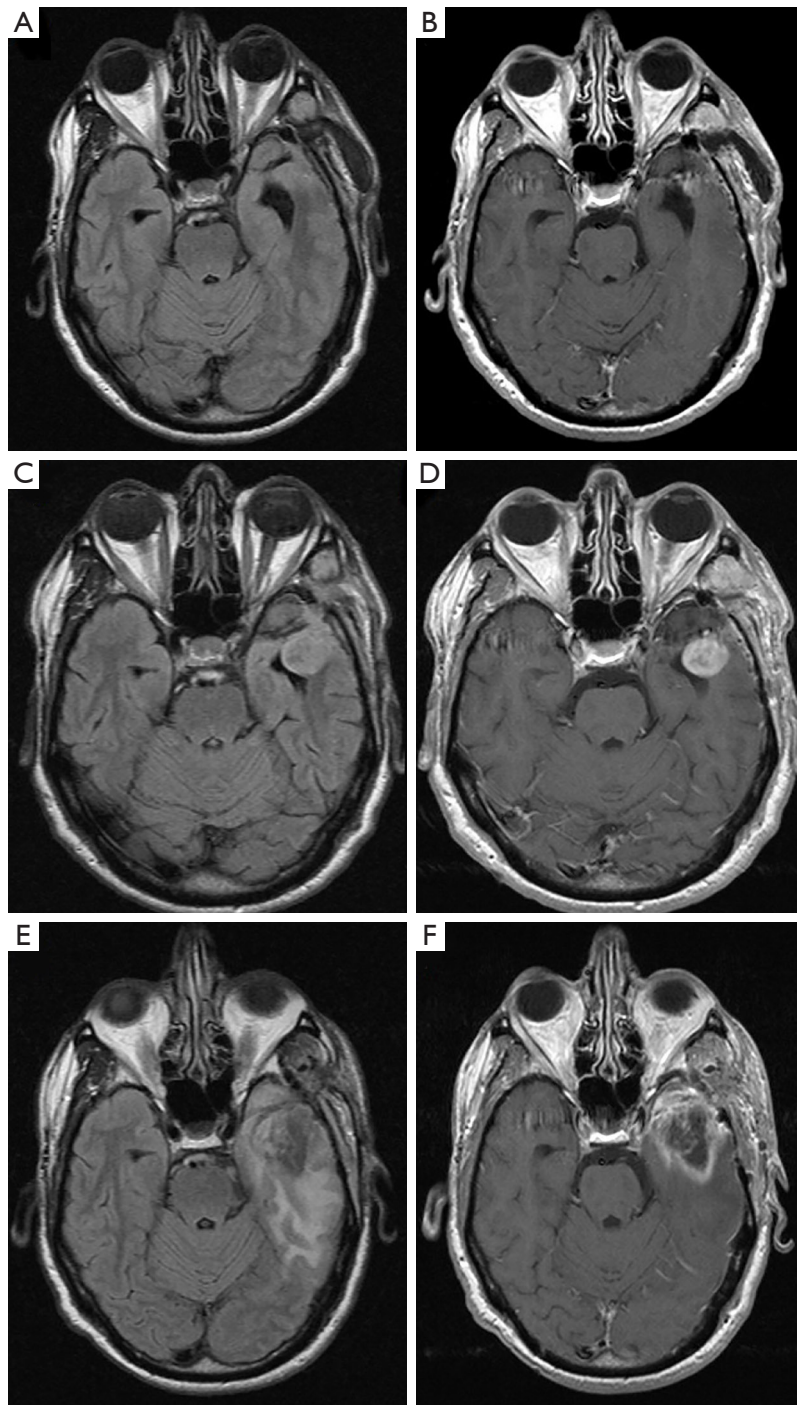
Astrocytoma grade 4 of the left temporal lobe surgically treated and subsequently underwent radiation therapy. (A,C,E) Axial FLAIR images; (B,D,F) axial T1 contrast-enhanced images. (A,B) MRI performed after 3 months from the surgery with no obvious signs of residual disease. (C,D) Follow up MRI performed after 1 months from A and B showing a nodular mass with contrast enhancement in the left temporal pole, highly suspected for disease recurrence. Half of the raters assigned a BT-RADS category 3c. However, given the worsening >25% in FLAIR and enhanced images, BT-RADS category 4 is more appropriate. (E,F) Follow up MRI after 2 months (<90 days) from the radiation therapy showing a worsening in FLAIR and enhanced images still to be interpreted as related to the treatment. All readers assigned a BT-RADS category of 3a. FLAIR, fluid attenuated inversion recovery; MRI, magnetic resonance imaging; BT-RADS, Brain Tumor Reporting and Data System.
